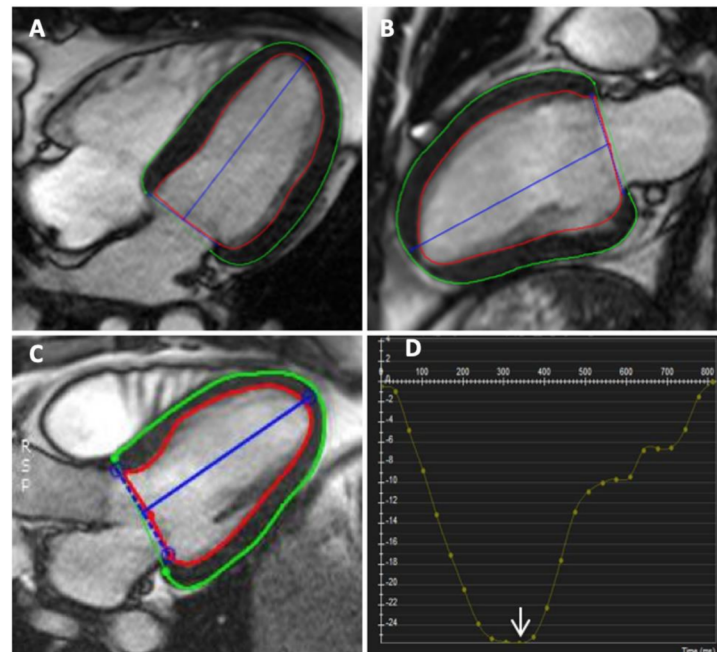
Long axis CMR assessment of 2D-strain using feature tracking by manually contouring endocardial and epicardial borders in end-diastole. (A): apical 4-chamber view, (B): apical 2-chamber view, (C): apical 3-chamber view, (D): myocardial strain curve with normal peak GLS measured (-26%).
